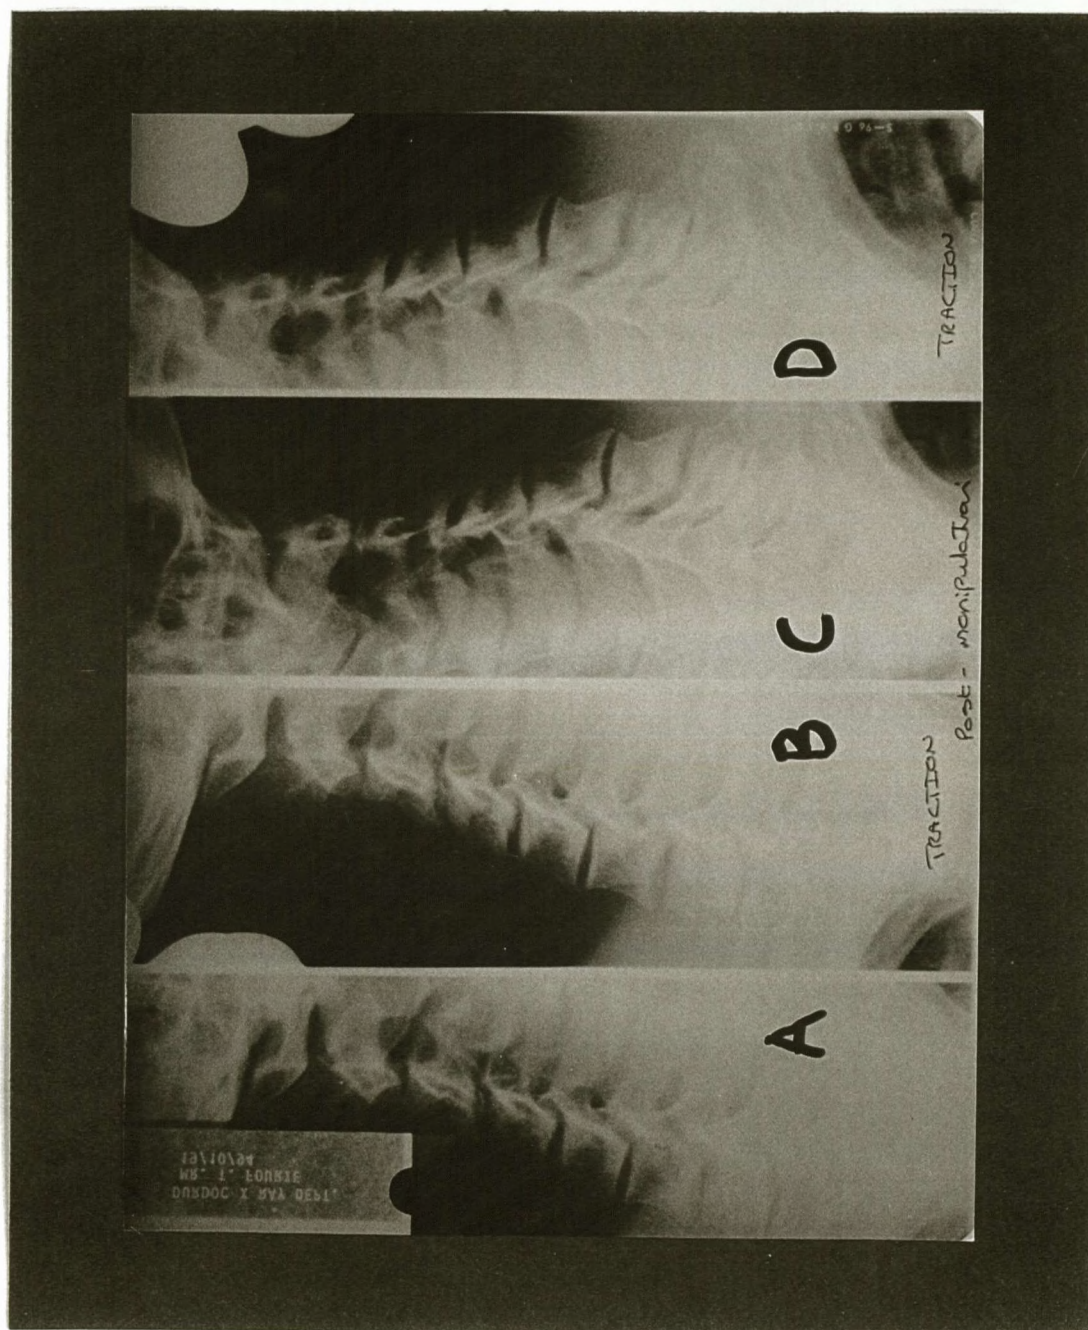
An example of a plain film radiograph of the resting zygapophyseal joints *after* manipulation (A and C) and the zygapophyseal joints *after* manipulation + 8kg traction (B and D). This radiograph is of the same subject shown in figure 6.
